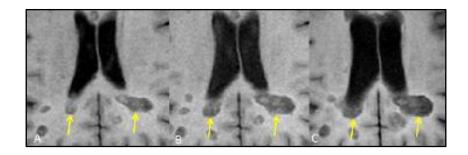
MRI T1 slowly expanding lesions.
